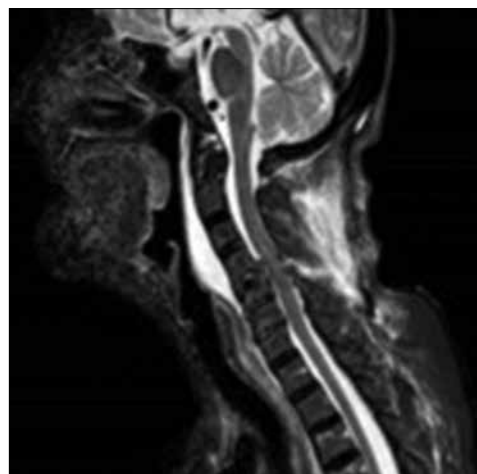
Sagittal T2-weighted demonstrating ligamentous and spinal cord injury
